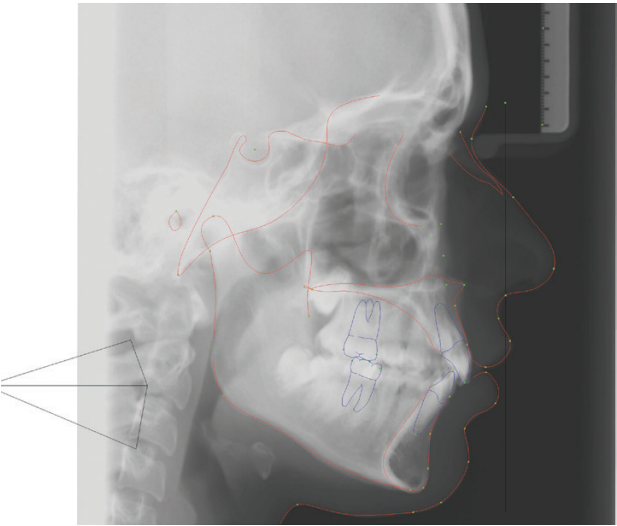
Cephalometric tracing of the skeletal analysis (SCA) and soft-tissue analysis performed on radiograph (rSTCA). The following measurements were evaluated: SNA°; SNB° and ANS-Me for SCA; A' to TVL; B' to TVL; and Sn to Me' for rSTCA.
